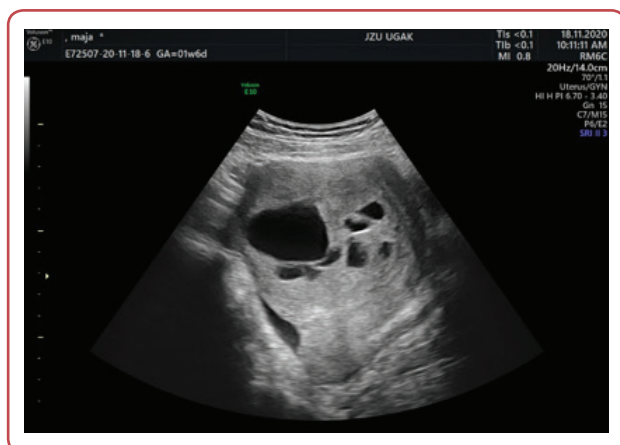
Transabdominal ultrasound - coronal section of a leiomyoma
